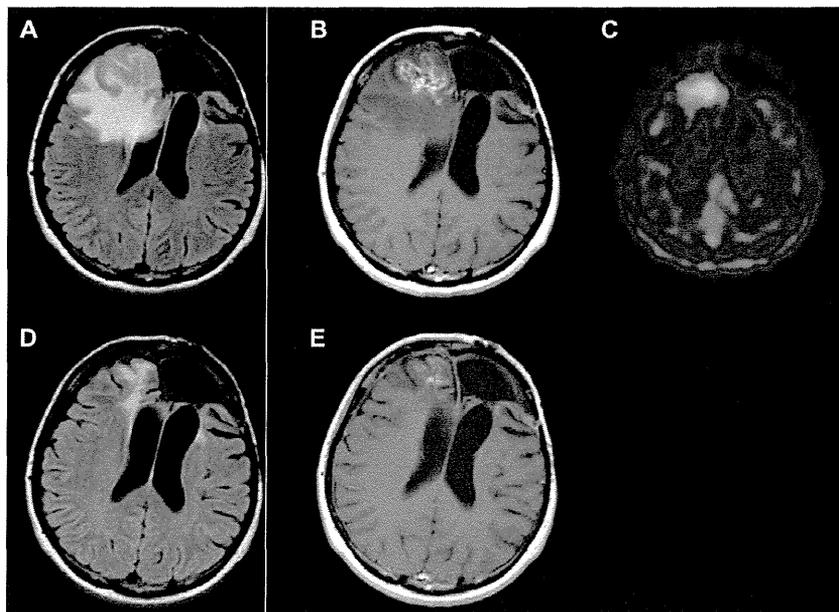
A 27-year-old woman (Case 8) with a left frontal anaplastic astrocytoma was treated with BNCT and X-ray radiotherapy after surgical resection. The patient had a convulsion due to enlarged perilesional edema 4 years later. MR images showed a heterogeneous enhancement with the massive perilesional edema in the right frontal lobe (A, B). The L/N ratio was 1.6 on F-BPA-PET (C). The patient was treated with bevacizumab. MR images after six cycles showed a remarkable reduction in perilesional edema and a weakening of the abnormal enhancement (D, E). The patient did not experience any further convulsions.
